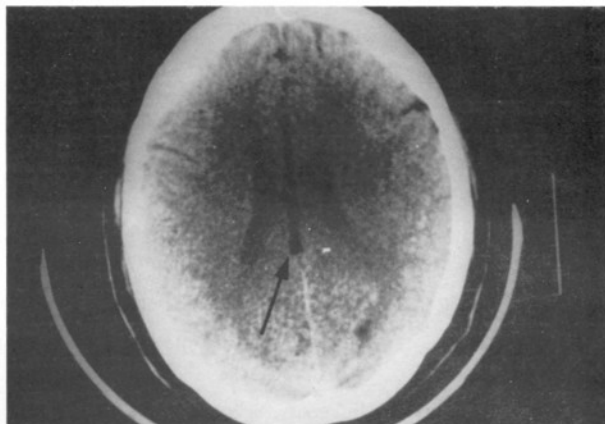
Case III. Axial CT scan showing a low hypodense lesion involving the corpus callosum from genu through the body into the splenium.
